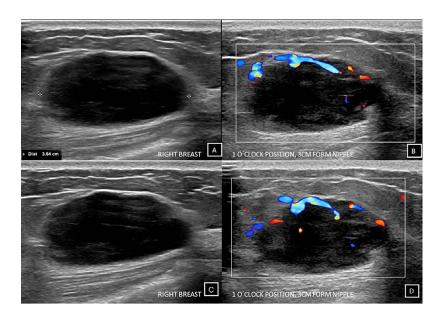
(A and C) Gray-scale ultrasound shows a 3.6 cm oval, hypoechoic, lobulated mass, localized at 1 oclock position, 3 cm from the nipple of the right breast. (B and D) Color Doppler demonstrates internal vascularity of the tumor. This mass corresponds with the findings described in the mammography.
